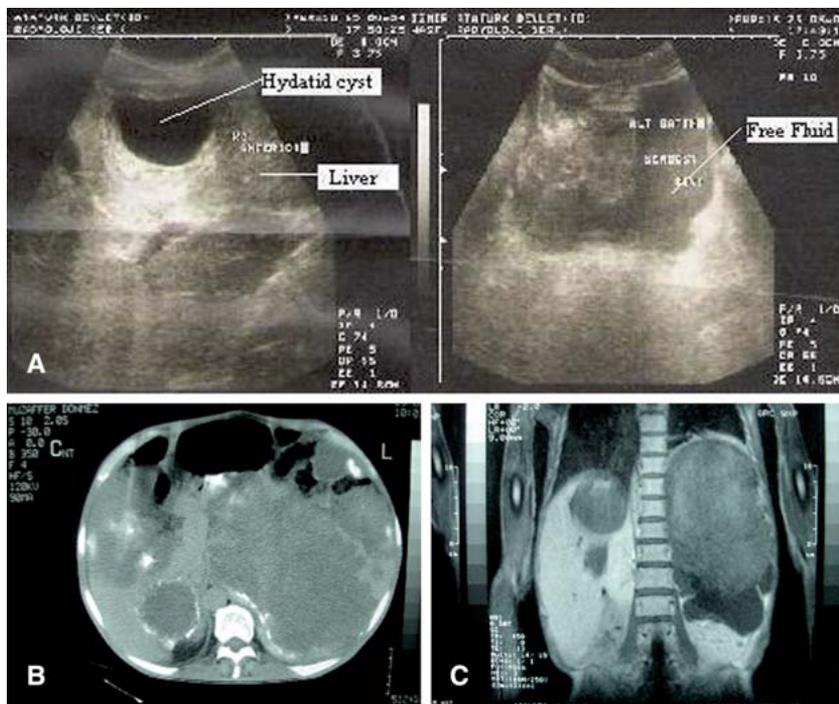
(A) US images showing ruptured hydatid cysts of the liver and free fluid in the abdomen. (B) CT image showing ruptured hydatid cysts of the liver and free fluid in the abdomen. (C) MR image showing hepatic cysts, and ruptured hydatid cyst that was located in the left hypocondrium.
